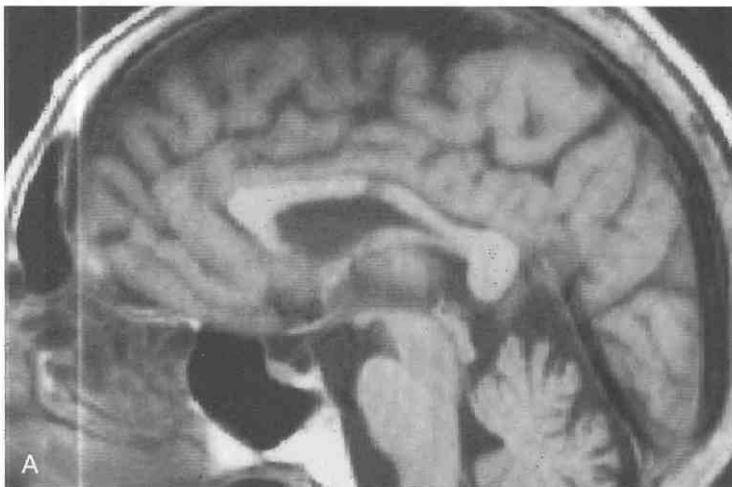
Marchiafava-Bignami disease. MRI demonstrates callosal and extracallosal demyelination. A, T1-weighted sagittal image of through-and-through demyelination focus in body of corpus callosum. B, T2-weighted axial scan with hyperintensities in corpus callosum as well as bilateral cerebral white matter.
